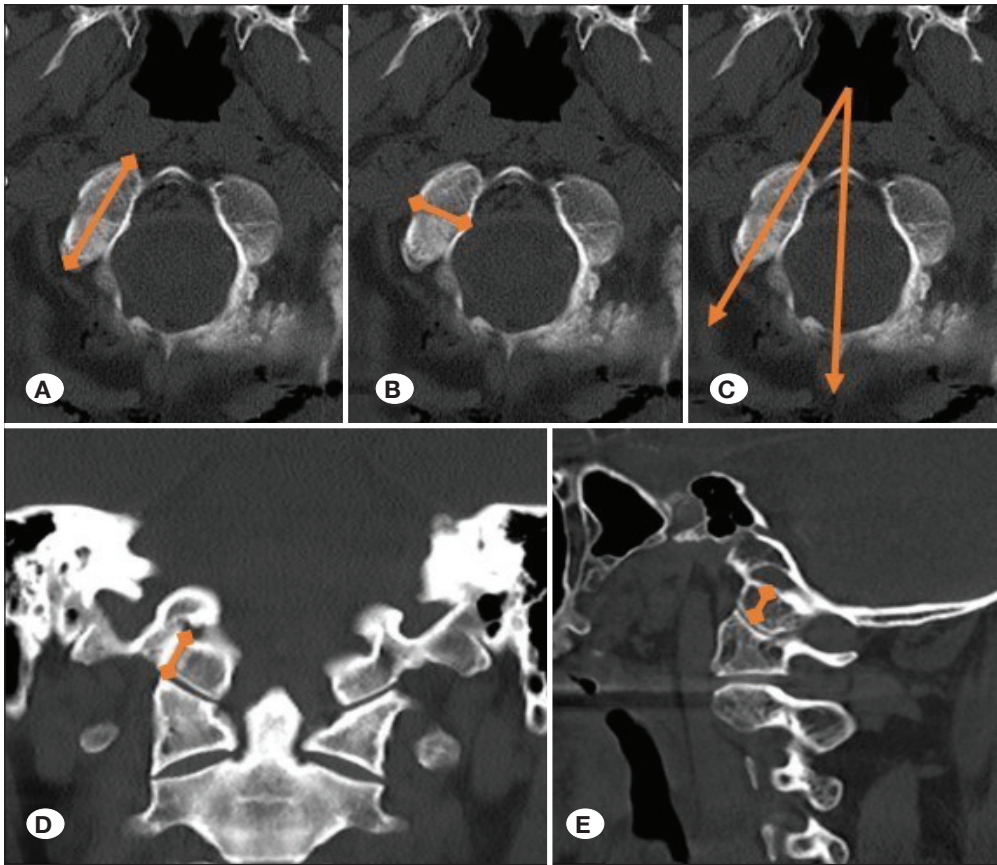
CT-based morphological characteristics of the OC. A) occipital condyle length (OCL), B) occipital condyle width (OCW), C) Occipital condyle angle (OCA), D) Occipital condyle height (OCH), E) Hypoglossal canal height (HGCH).
